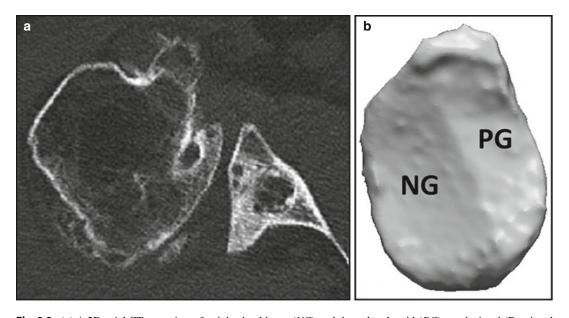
(a) A 2D axial CT scan view of a right shoulder demonstrating an asymmetric type B2 glenoid. (b) A sagittal view of a 3D CT reconstruction demonstrating a B2 glenoid with posteroinferior erosion. The neoglenoid
